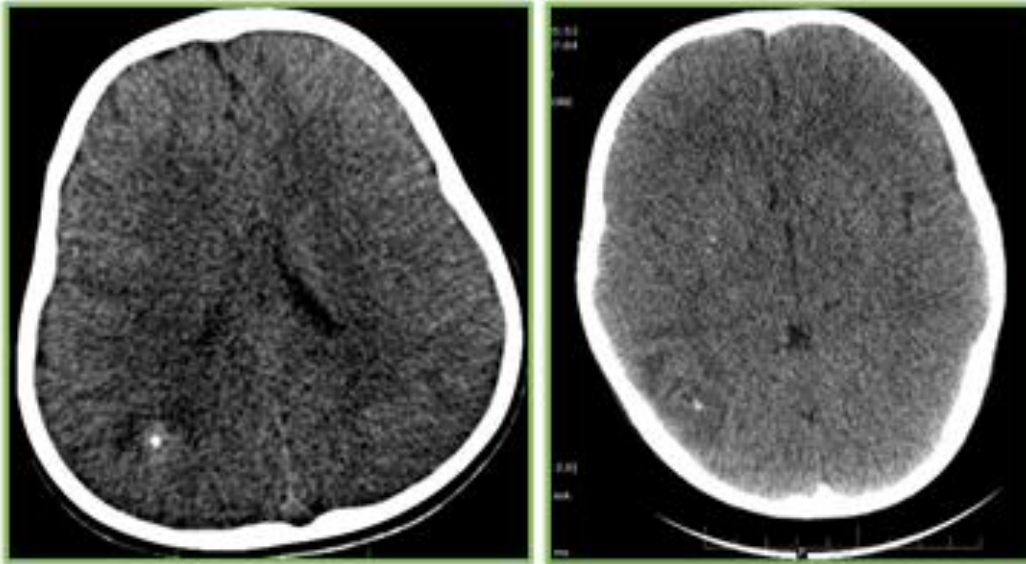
a) Nonenhanced CT scan in a) 5-year old child with seizures, shows calcified neurocysticercosis in right parietal region. b) 9-year old child with seizures, shows calcified neurocysticercosis with profuse perilesional edema in right parietal region.
